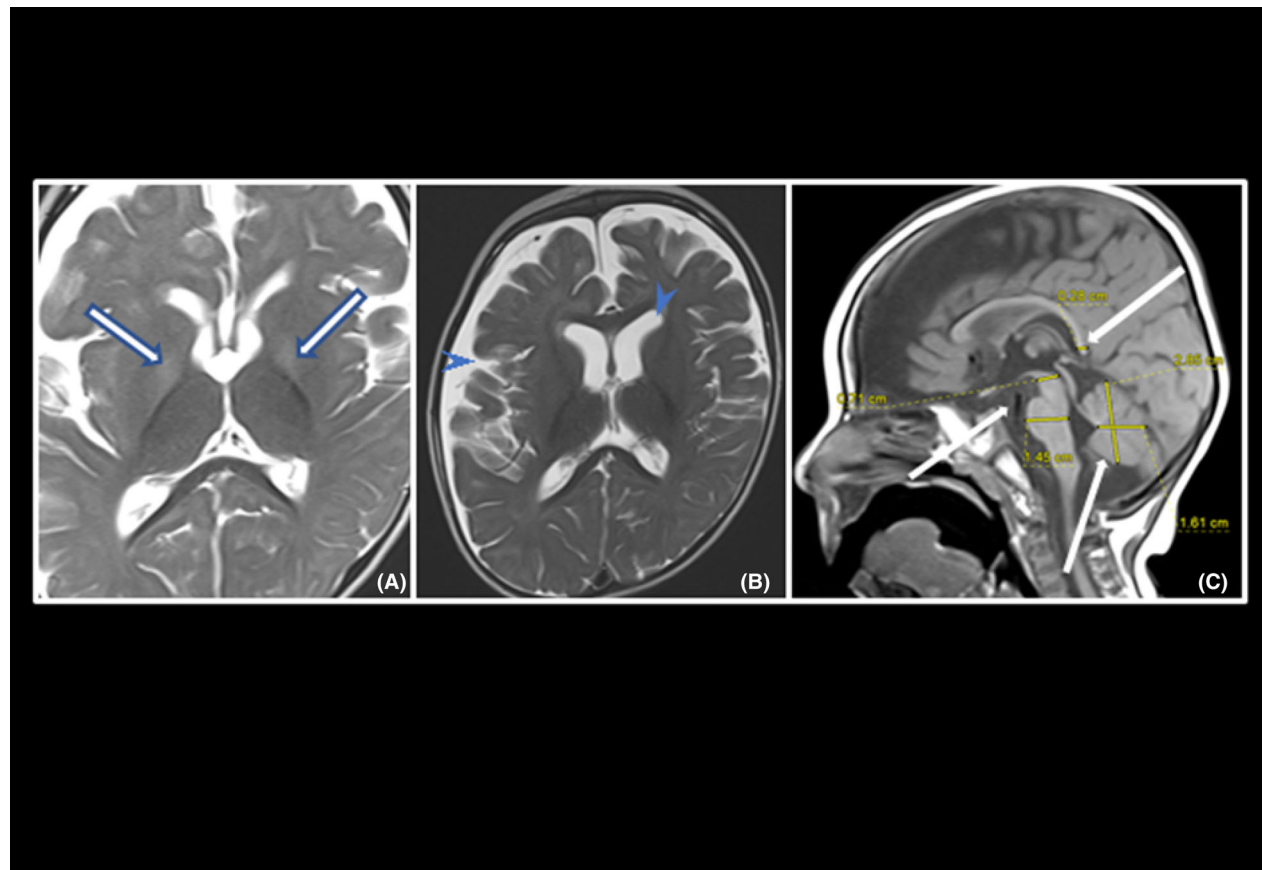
Brain MRI at the age of 10 months showed (A) subtle bilateral and symmetrical globus pallidus hyperintensities (Axial, T2-WI, blue line arrows) (B) enlargement of the ventricles and subarachnoid spaces associated to diffuse brain atrophy (Axial, T2-WI, arrow heads), and (C) thin corpus callosum and mild atrophy of the brainstem and cerebellar vermis (Sagittal, T1-WI, white arrows).
